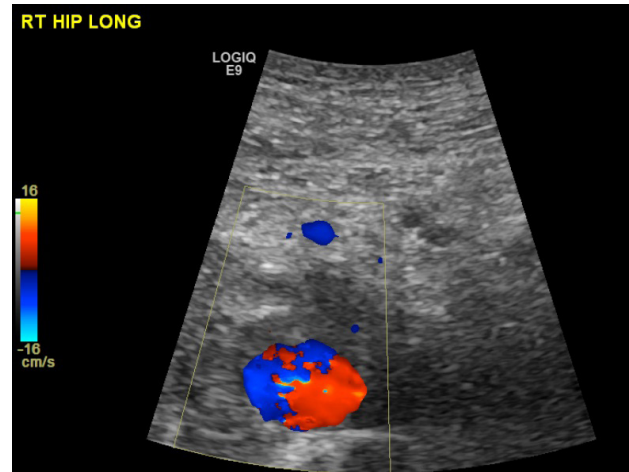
Doppler ultrasound appearance of yin-yang colour form suggestive of pseudoaneurysm.
